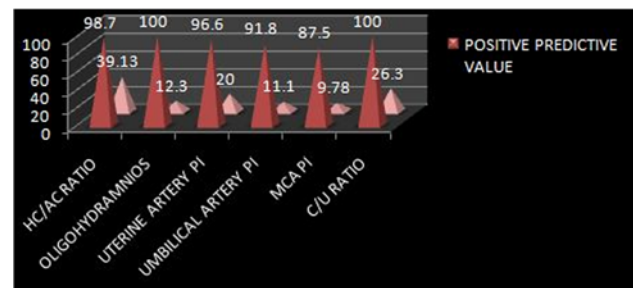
A comparison of predictive values of various gray scale and doppler indices
